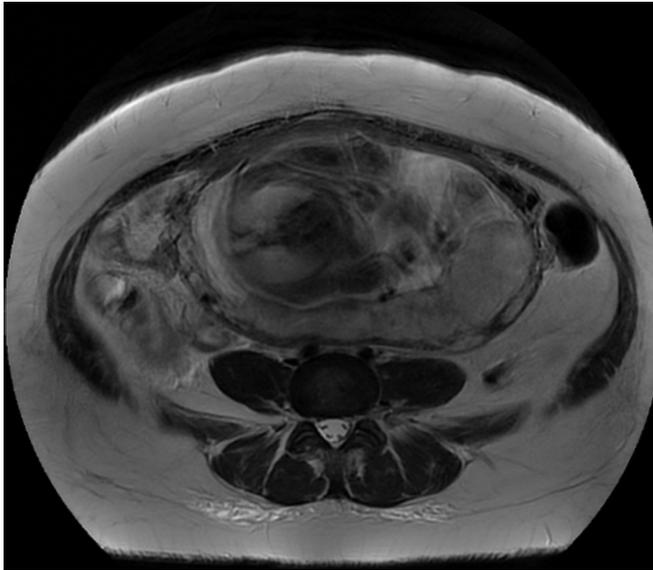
MRI demonstrating acute appendicitis in pregnancy: intrauterine pregnancy with acute inflammatory mass present adjacent to the cecal pole, medially and posteriorly, with edema of the fat and a small volume of free fluid. Appendicoliths are present within the distended edematous appendix, with a small fluid collection immediately adjacent. Case courtesy of Vikas Shah, Radiopaedia.org, rID: 87388.
